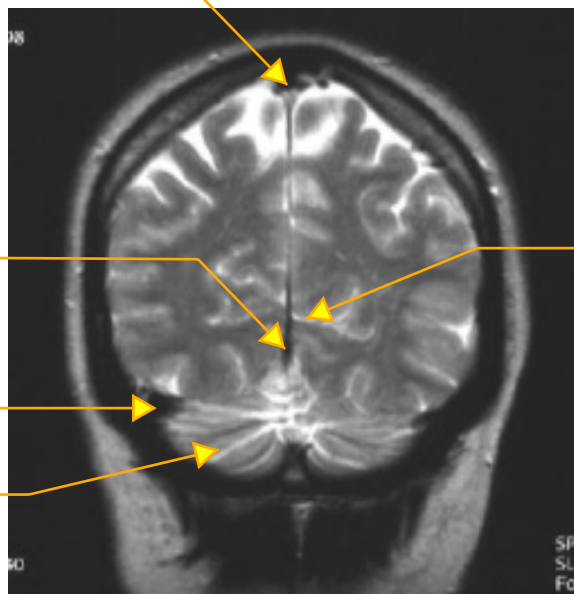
Coronal MRI (T2) through the occipital lobe. (From R, Swenson, Dartmouth Medical School)
